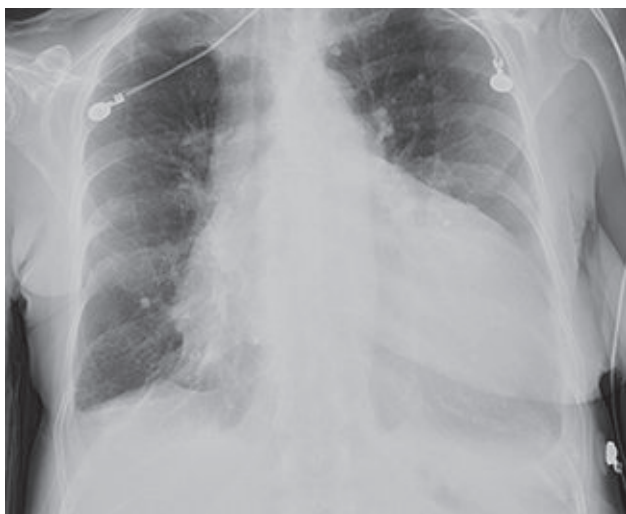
Chest X-ray revealing large pericardial effusion and small bilateral pleural effusions.
